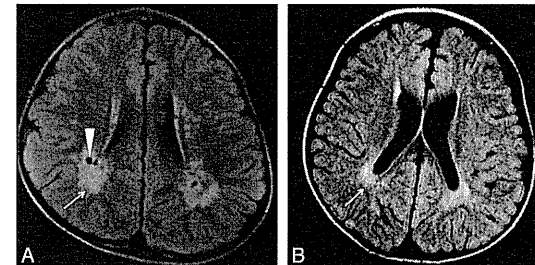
Type 2. White matter abnormalities, especially around the trigones. FLAIR image of a 4-year-old patient (case 22) (A) with an *ATRX* mutation of the chromatin-remodeling domain in exon 19 (p.V1624M), and a 35-month-old patient (case 21) (B) with an *ATRX* mutation of the chromatin-remodeling domain in exon 19 (p.A1622V). Increased signal intensity on T1WI/FLAIR in the periventricular region, especially around the peritrigonal area (arrow), and enlargement of perivascular space (arrowhead) are seen.
